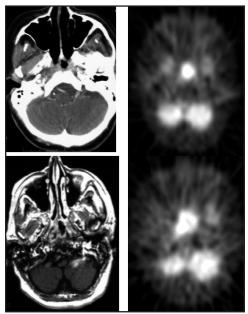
Recurrent nasopharyngeal cancer detected by PET and not CT (top). Recurrent nasopharyngeal cancer detected by PET and MRI (bottom).
